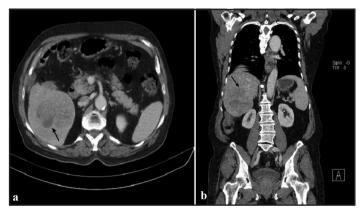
(a) Axial contrast enhanced CT image of the abdomen shows an irregular heterogeneously enhancing mass lesion in right lobe of liver; (b) Coronal contrast enhanced CT image of the abdomen shows the craniocaudal extent of hepatic mass.
